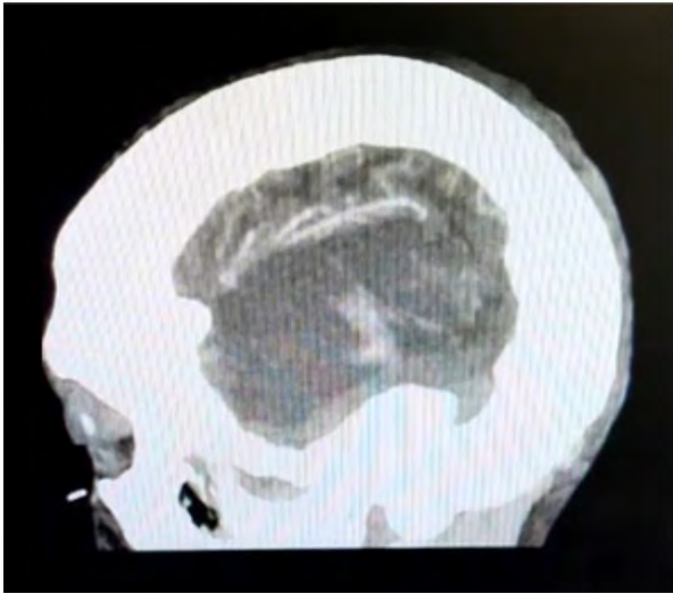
Pre-operative CT. Sagittal view.
